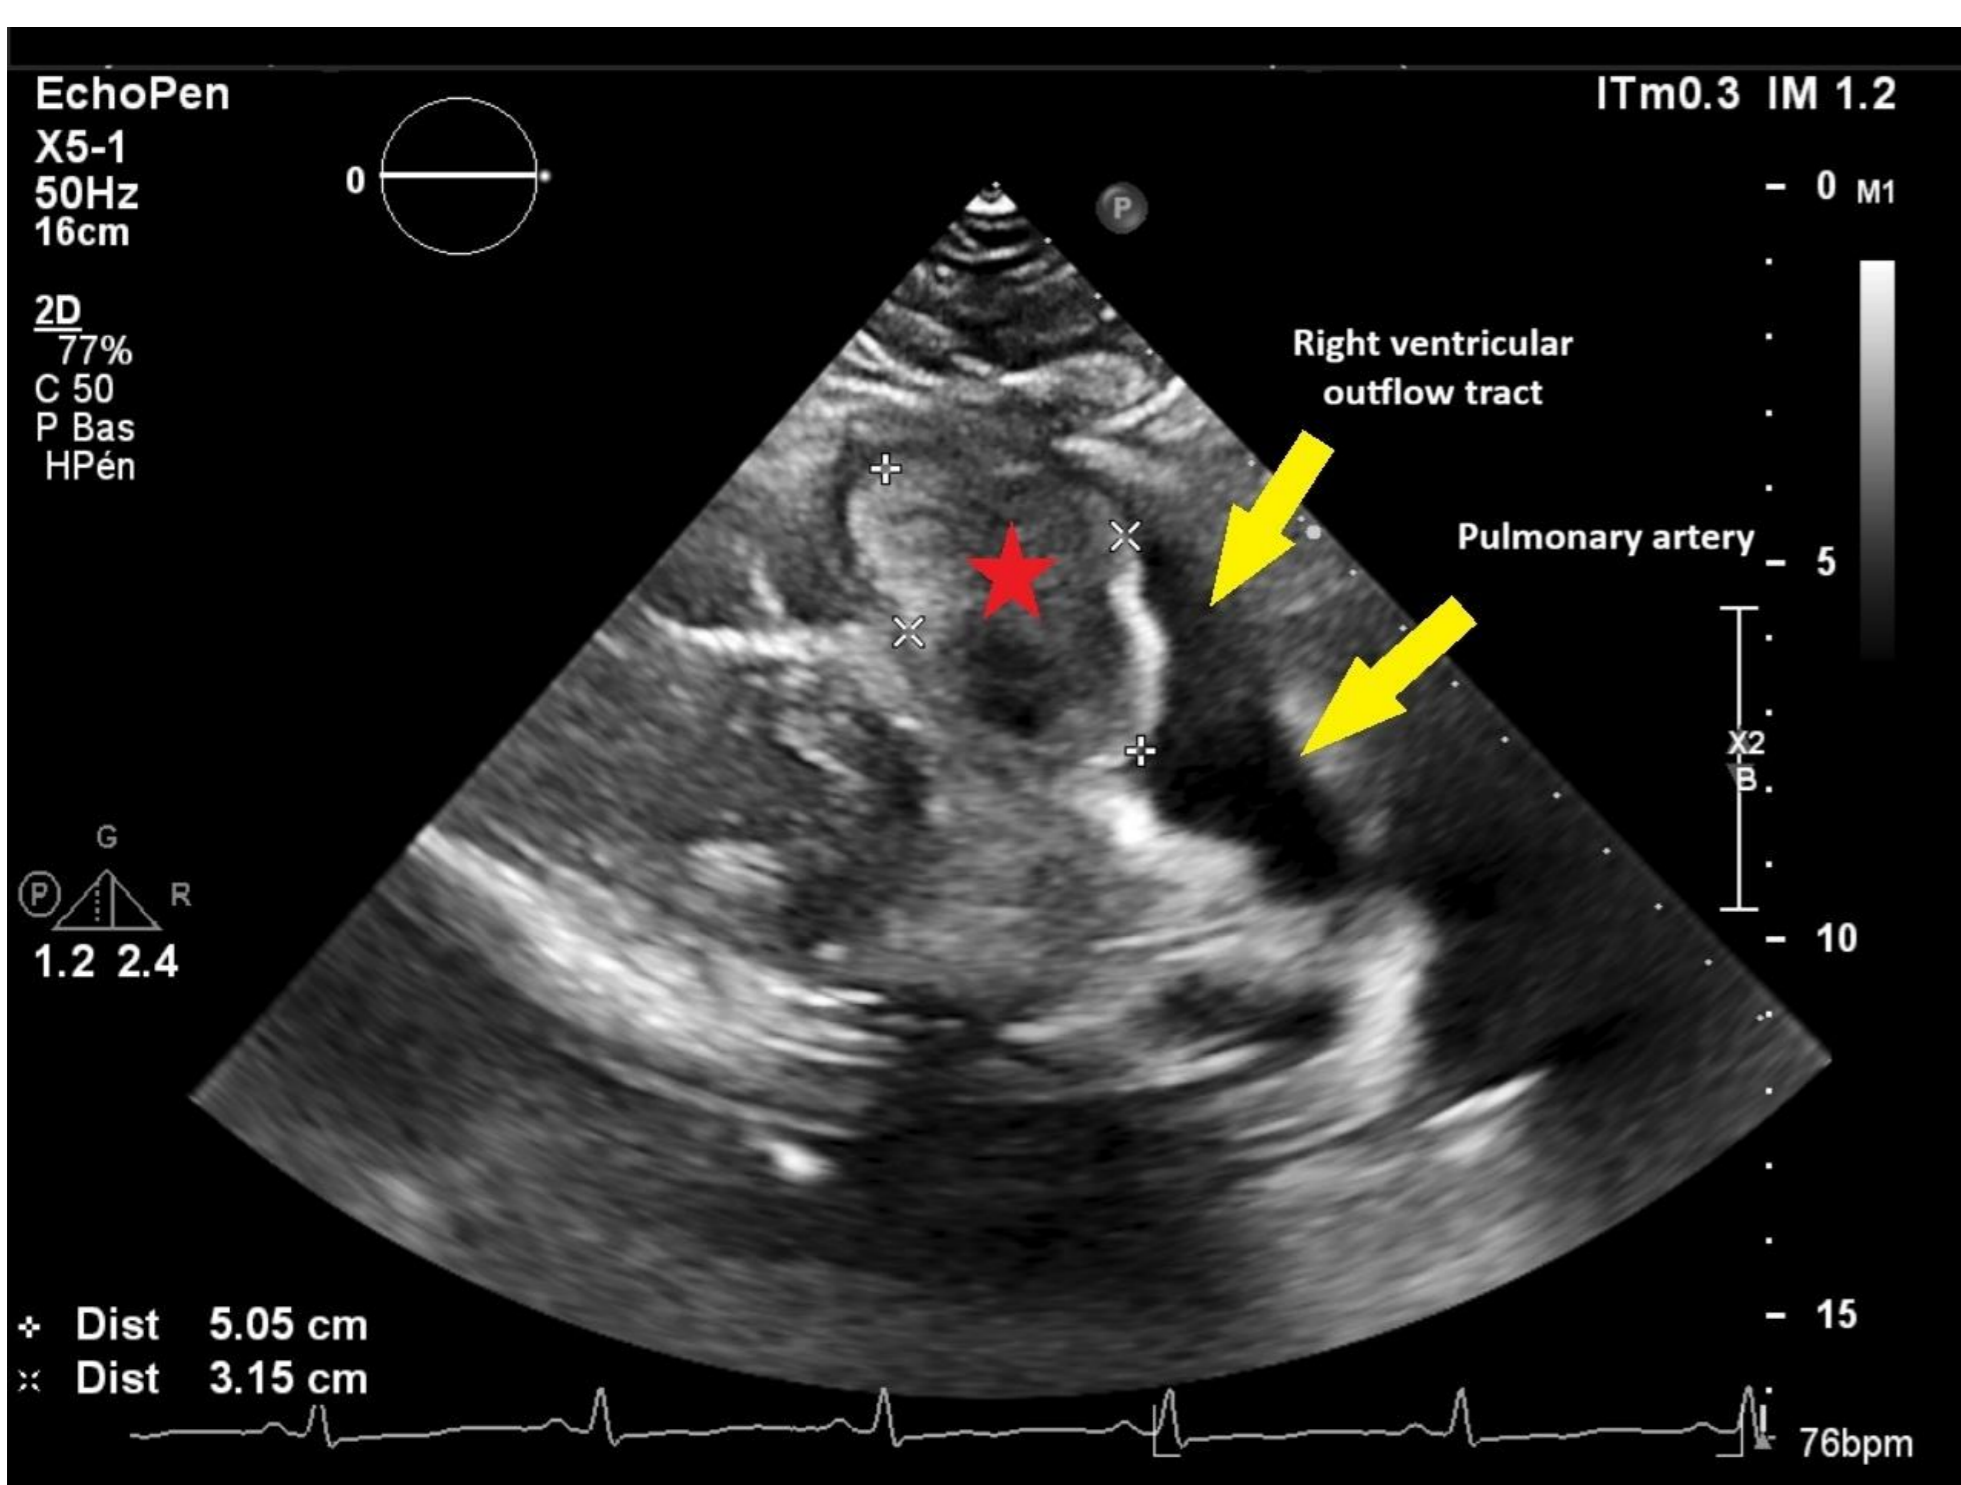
2D TTE, parasternal long-axis view of the right ventricular outflow tract, demonstrates a 50 × 31 mm hyperechogenic mass (red star)
